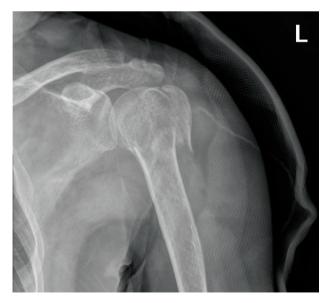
Left shoulder X-ray - Preoperation (October 10, 2018).
